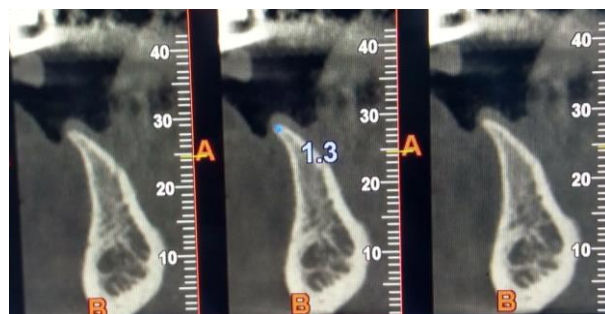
Measurement of crestal cortical bone thickness in mandibular arch by CBCT.
